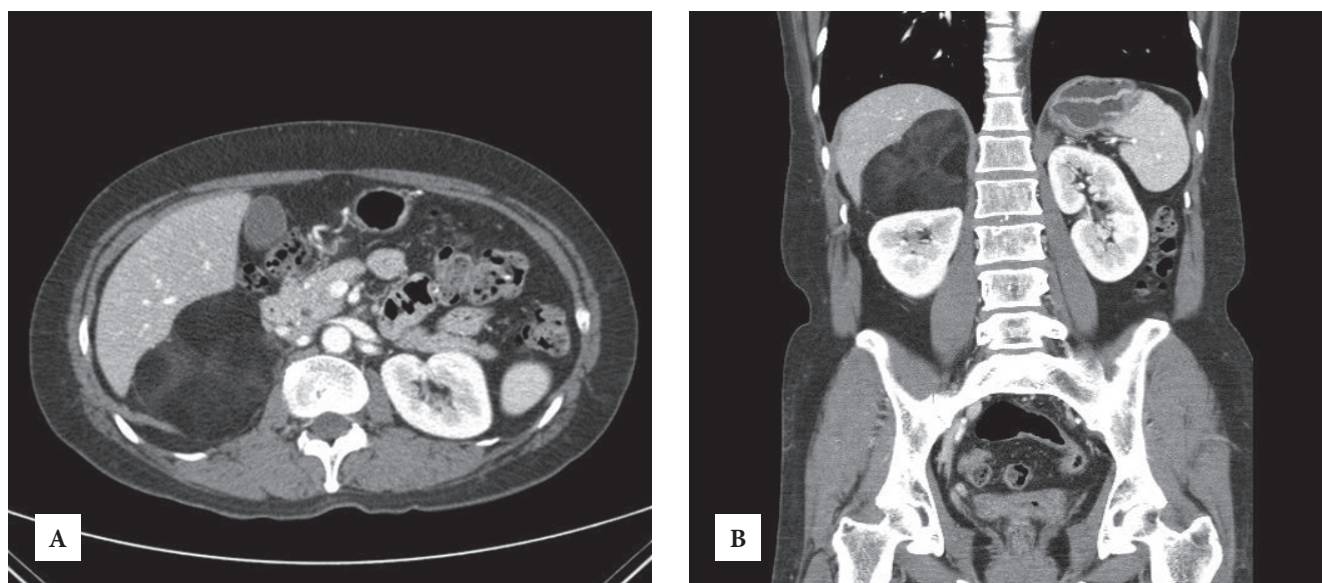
Abdomen pelvic computed tomography. (A),(B): Abdomen CT shows a lobulated contour heterogeneous fatty density mass with peripheral calcifications in right adrenal gland (maximum diameter 8.9 cm).
